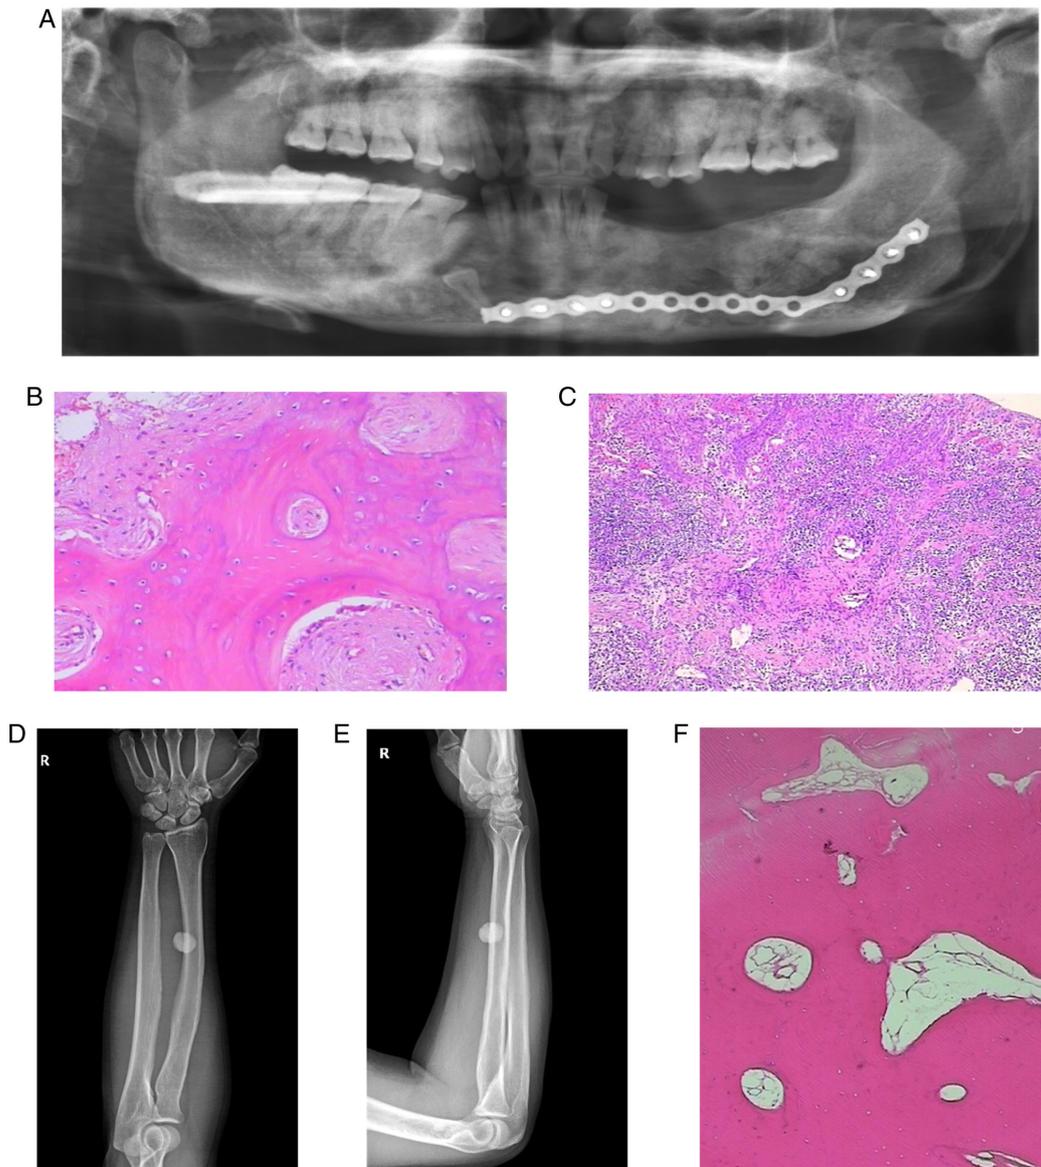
(A) Postoperative oral X-ray, panoramic film. (B and C) Pathological sections on hyperosteozytoma tissues of the left and right mandibular bone (magnification, x400 and x100, respectively). (D) The radius and ulna of right forearm on anteroposterior radiograph. (E) The radius and ulna of right forearm on lateral radiograph. (F) Pathological sections on hyperosteozytoma tissue of the right tibia (magnification, x400).
